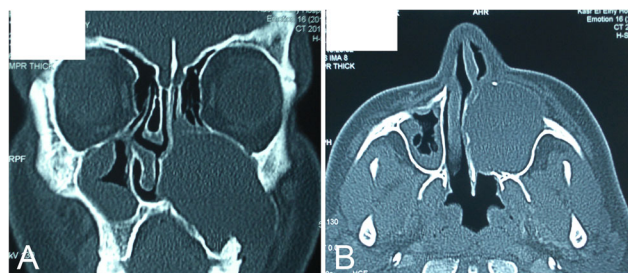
A preoperative computed tomography for the paranasal sinuses. a Coronal and b axial views show completely opacified right maxillary sinus with homogenous cyst-like lesion and pushed nasal septum to the opposite side
